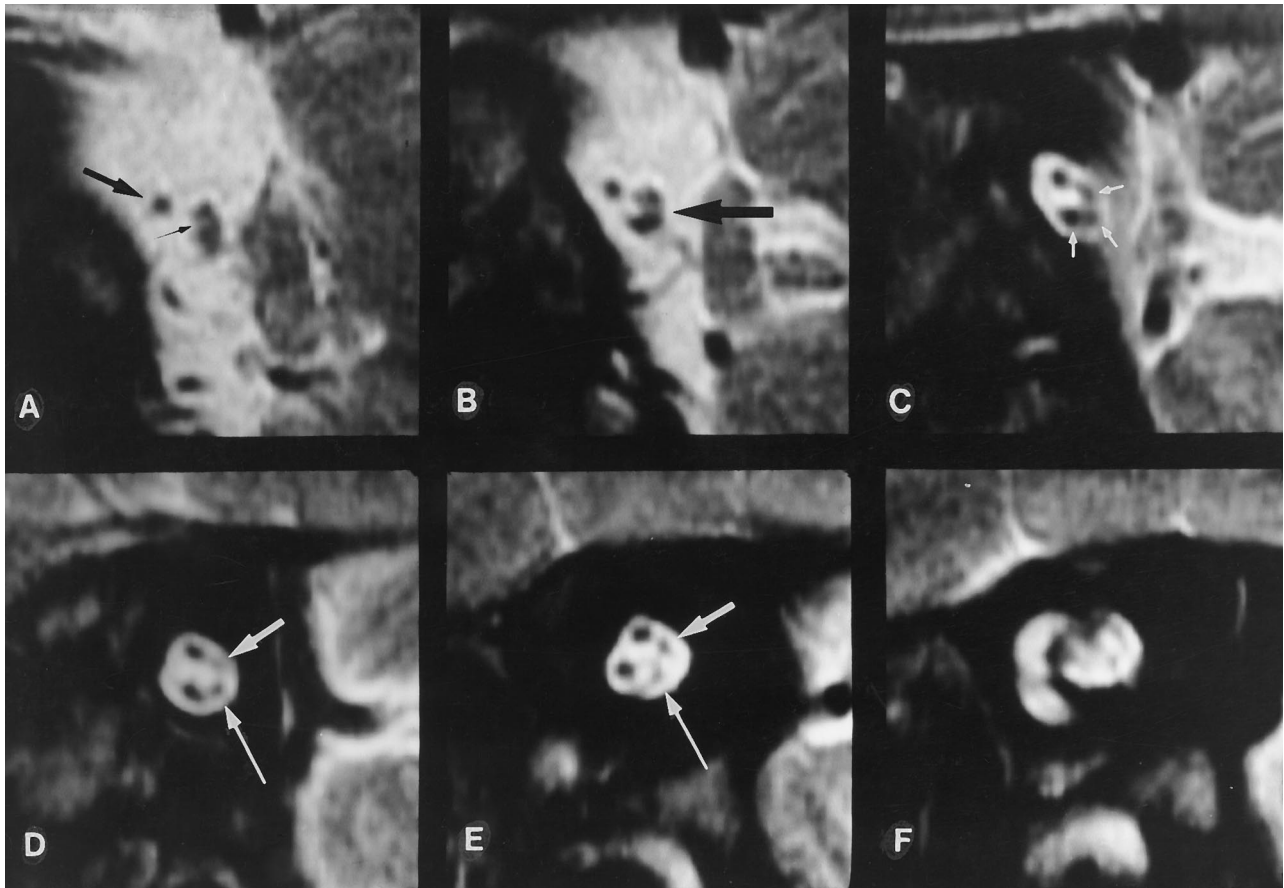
3-mm-thick oblique parasagittal FSE T2-weighted images show topographical relationship of the facial and vestibulocochlear nerves.
